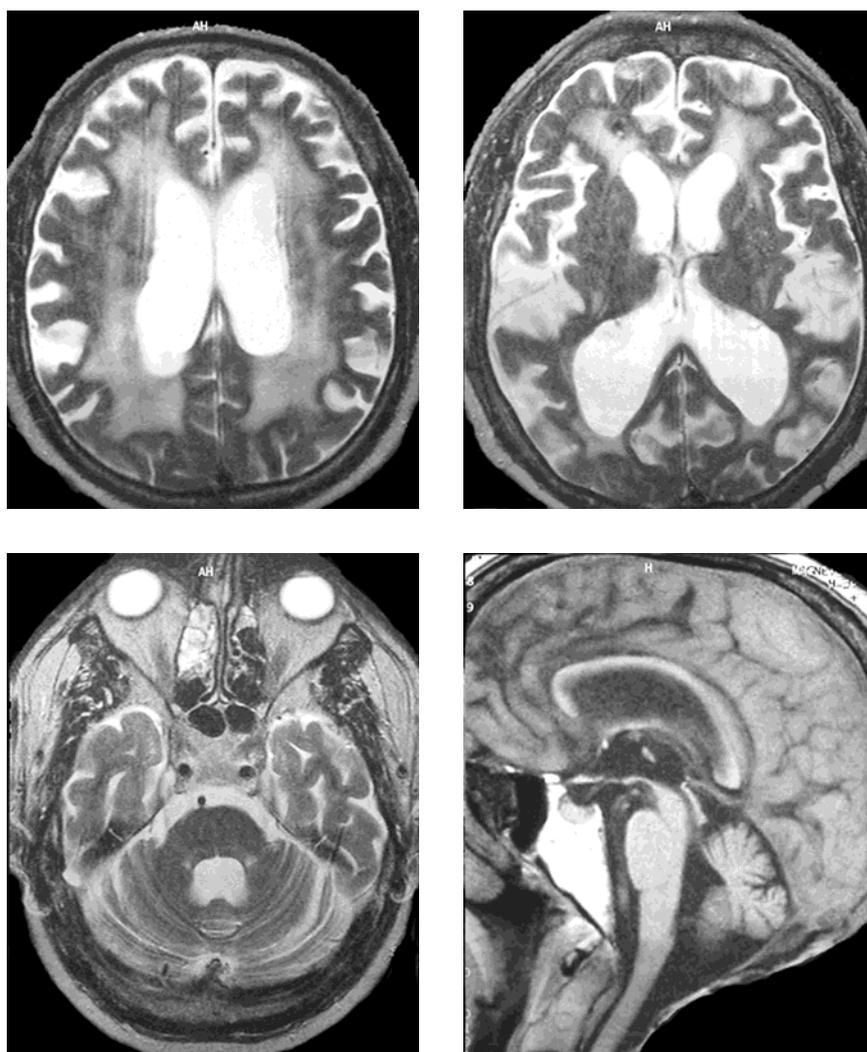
Brain MRI performed 5 years after clinical onset. Cut at the level of the lateral ventricles (left upper view) and the basal ganglia-thalami region (right upper view). The T2 weighted axial MRI shows severe ventricular enlargement, moderate cortical atrophy, confluent symmetrical high signals in the white matter and no multiple and/or strategically located infarcts. In contrast, the temporal poles appear relatively spared (left lower view). Note the decreased size of the corpus callosum on the T1 weighted mid-sagittal section (right lower view)
